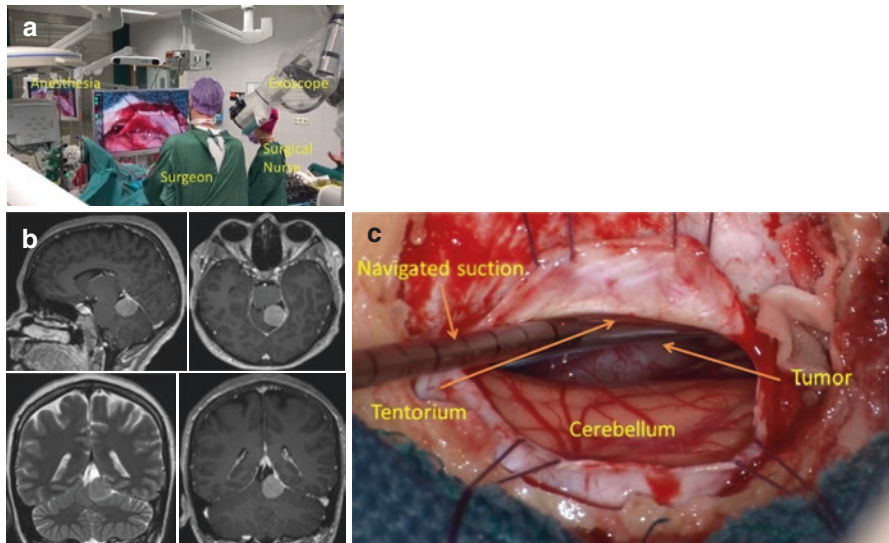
Operative set-up for pineal region tumor surgery. Position of surgeon, exoscope, anesthesia and surgical nurse (a). Pre-operative MRI scans (b) and intra-operative view of a tentorial meningioma (c) nearly reaching pineal region (Taken from Muhammad et al. 2019 [108])
